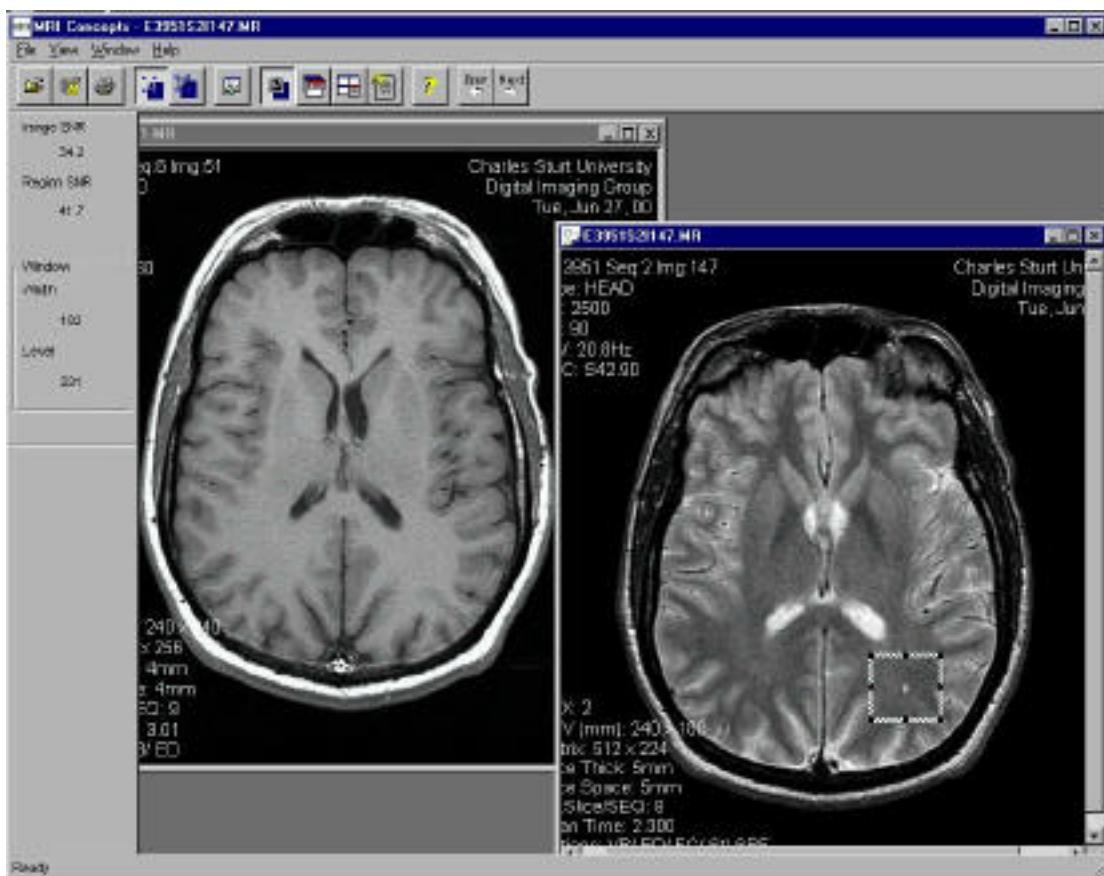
MRI Concepts*: A Microsoft Windows compatible program
